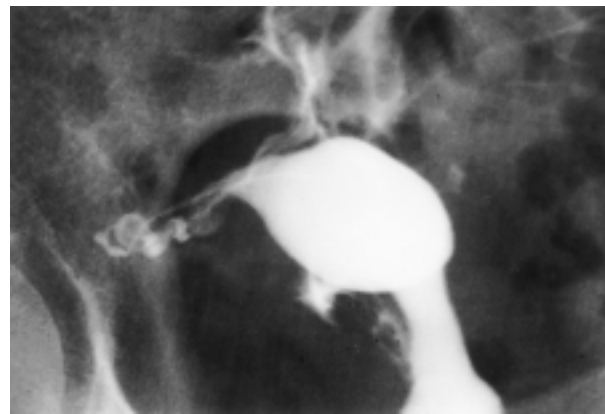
Selective salpingography of the right fallopian tube. (a) Radiograph shows a 0.035-inch guide wire supported by a 5.5-F catheter that was used to catheterize the right tubal ostium. (b) Radiograph, obtained after the catheter was wedged firmly into the tubal ostium and after injection of contrast material, demonstrates the fallopian tube, which cannot be seen with conventional hysterosalpingography.
